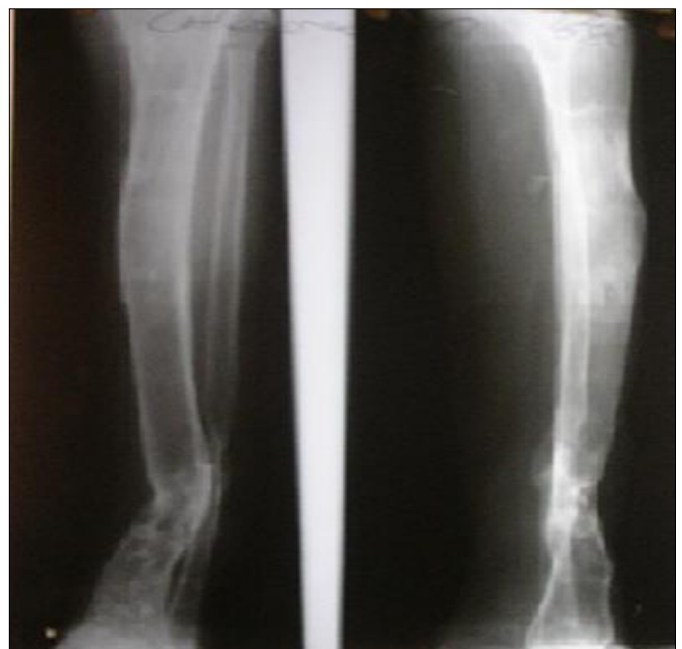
X-ray showing post ring Removal with the consolidation of regenerate.
